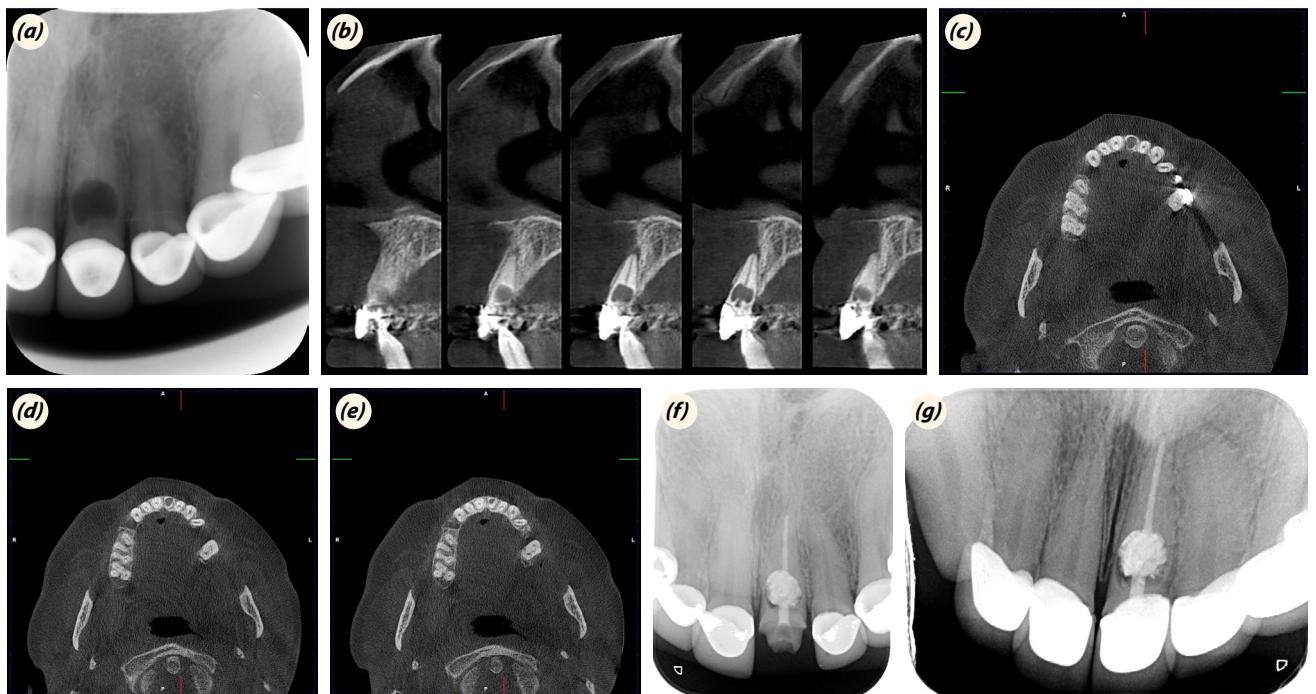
Case 2, (a) initial, (b) CBCT sagittal view, (c) axial view 1, (d) axial view 2, (e) axial view 3, (f) post-treatment radiograph, (g) 1 year follow-up.
